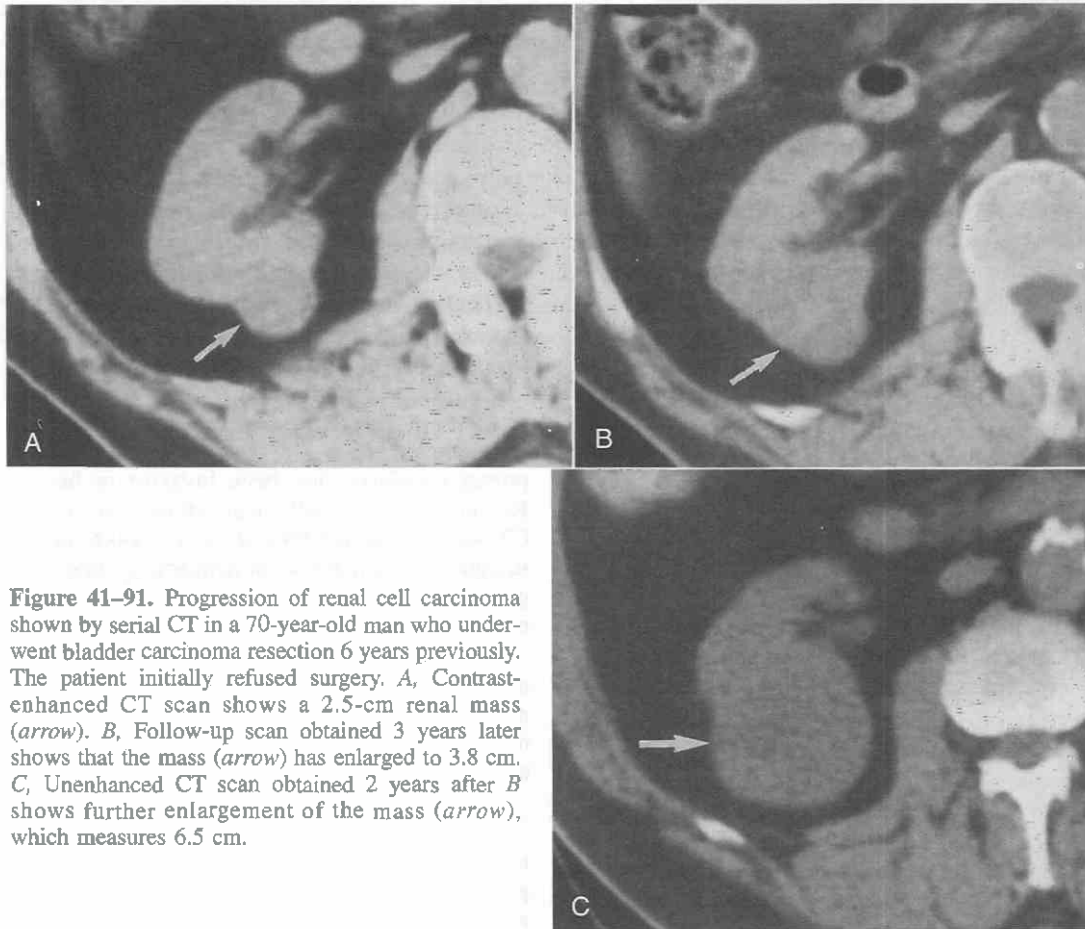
Progression of renal cell carcinoma shown by serial CT in a 70-year-old man who underwent bladder carcinoma resection 6 years previously. The patient initially refused surgery. *A*, Contrast-enhanced CT scan shows a 2.5-cm renal mass (arrow). *B*, Follow-up scan obtained 3 years later shows that the mass (arrow) has enlarged to 3.8 cm. *C*, Unenhanced CT scan obtained 2 years after *B* shows further enlargement of the mass (arrow), which measures 6.5 cm.
